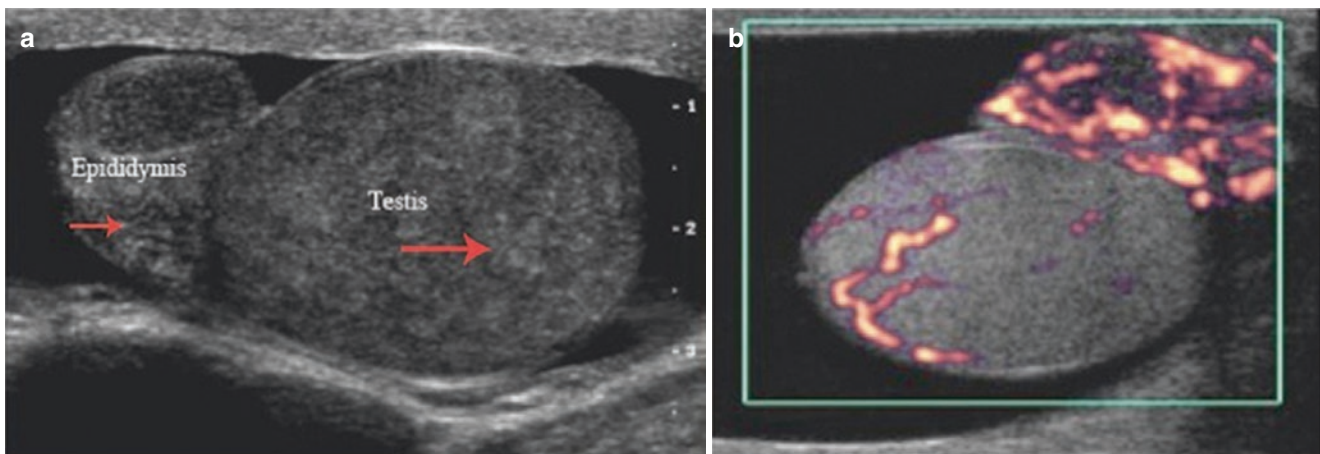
(a) Epididymo-orchitis. Both the epididymis and testis are enlarged, with multiple hypoechoic patches on the testis. (b) Power Doppler shows increased vascular flow in the epididymis. (From Gilbert [3]; with permission)
